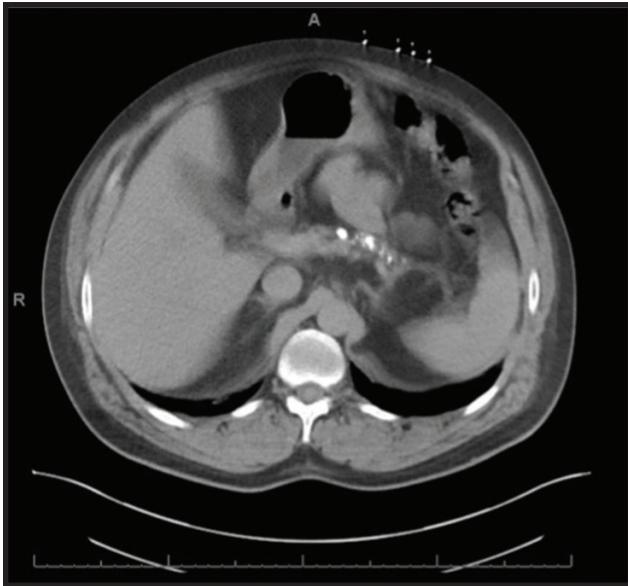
Presence of Pancreatic Calcifications on CT
